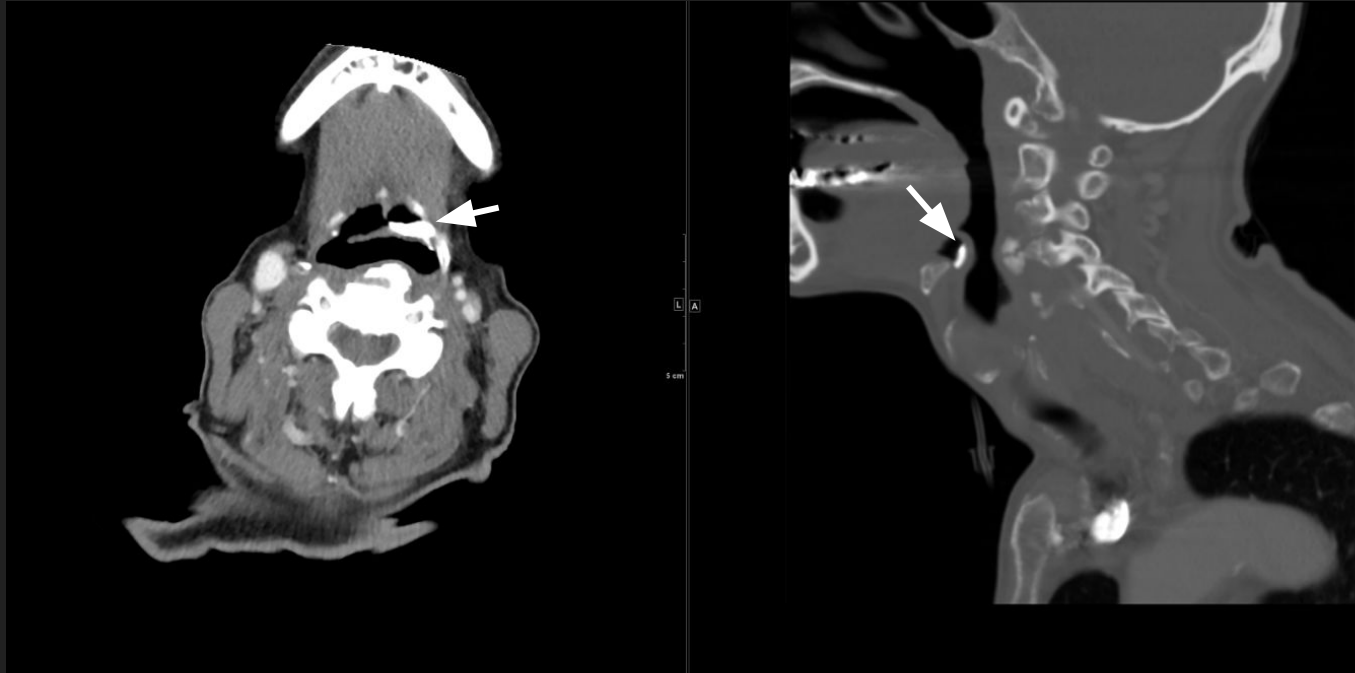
CT of the neck demonstrating ossification of the left aspect of the epiglottis (white arrow).
